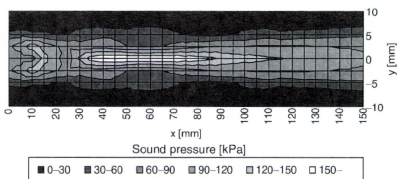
Two-dimensional distribution of sound pressure of the 3MHz transducer. (x-axis indicates the direction of ultrasound propagation, and the line of $x = 0$ corresponds to surface of the transducer).
